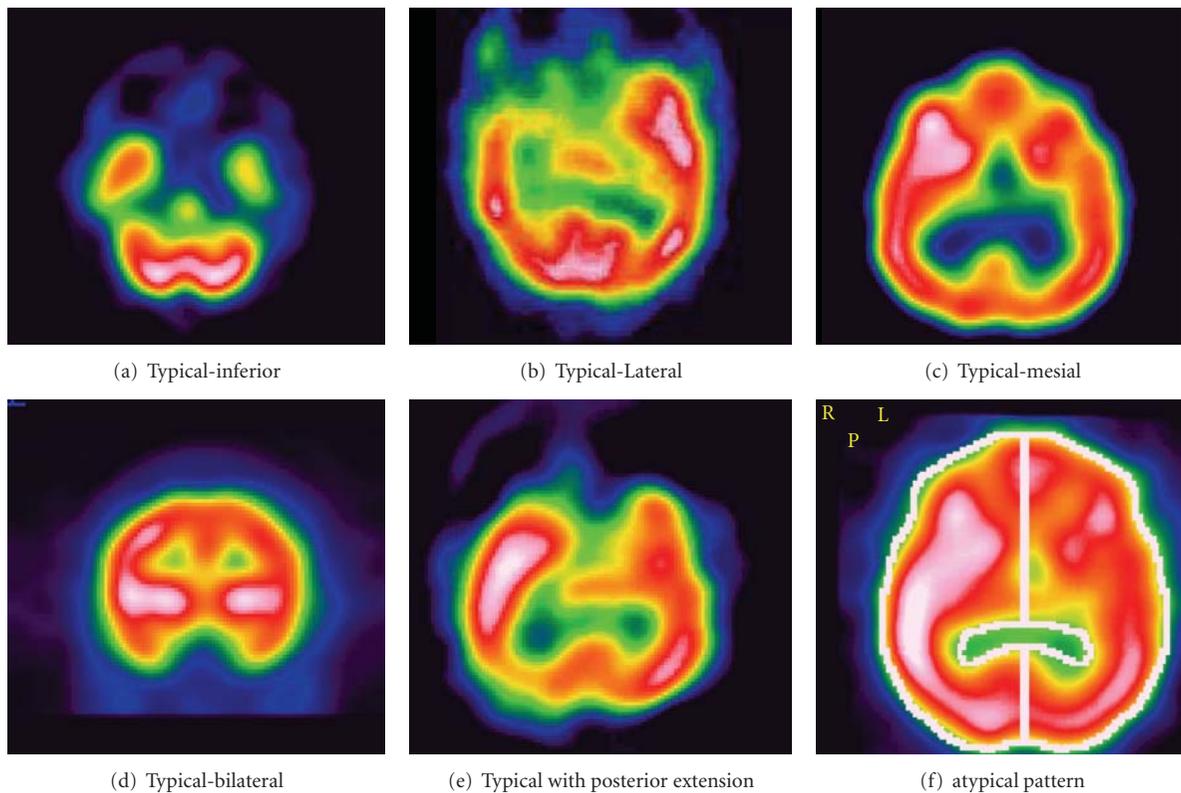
Ictal SPECT patterns in temporal epilepsy as described by Ho et al. [27].
